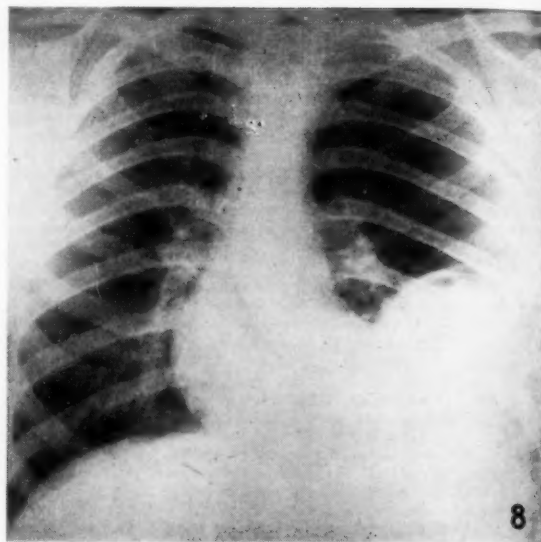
Case 4. P.A. radiograph showing the left basal opacity with a small fluid-level.
